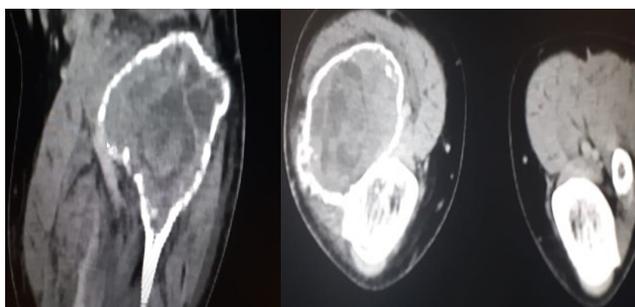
MRI shows lytic lesion over subarticular region with internal septation having a “bubbly” appearance involving left fibula with mass effect on lateral tibial plateau.
